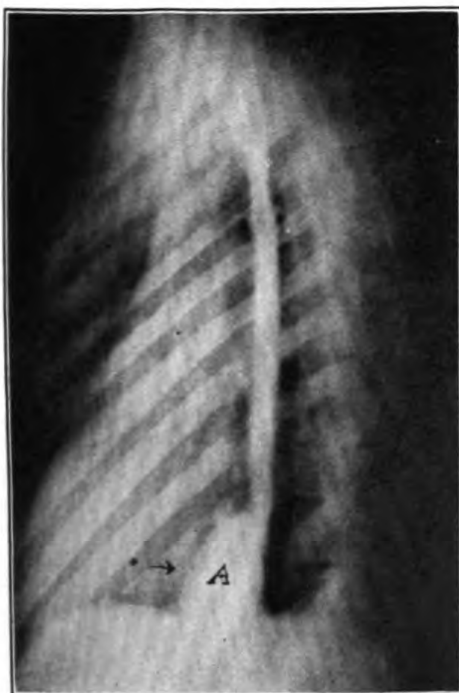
ROENTGENOGRAM SHOWING THE ESOPHAGUS WITH THE APPARATUS DILATING THE LOWER STRICTURE
